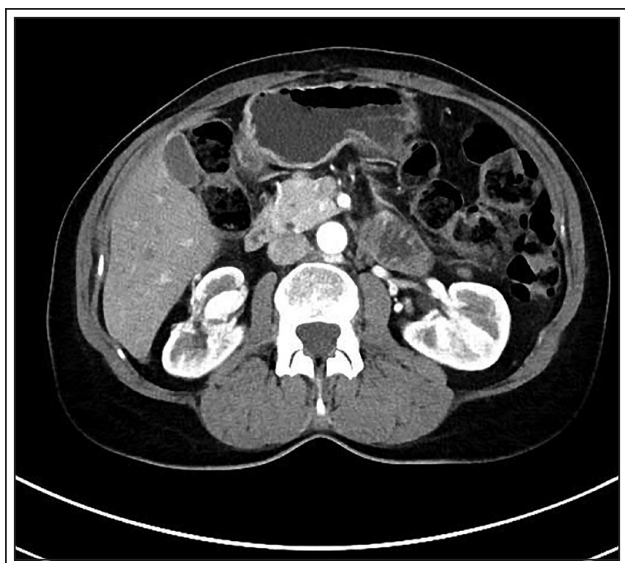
CT abdomen pelvis with and without IV contrast 2 years post right robotic partial nephrectomy.
